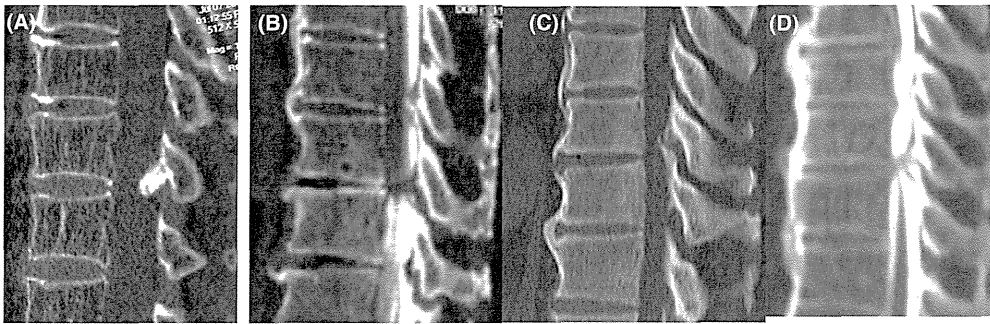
The CT sagittal classification of OALL at the OLF level. (A) No discernible OALL immediately rostral or caudal to the most severe OLF level (type N); (B) one-sided (type O), in which the OALL exists either immediately rostral or caudal to the most severe OLF level but not at the most severe OLF intervertebral level; (C) discontinuous (type D), in which the OALL is present both rostrally and caudally to the most severe OLF level but not at the most severe OLF level; and (D) continuous (type C), in which the OALL extends from the rostral to the caudal levels, including the most severe OLF level. CT indicates computed tomographic; OALL, ossified anterior longitudinal ligament; OLF, ossification of the ligamentum flavum.
